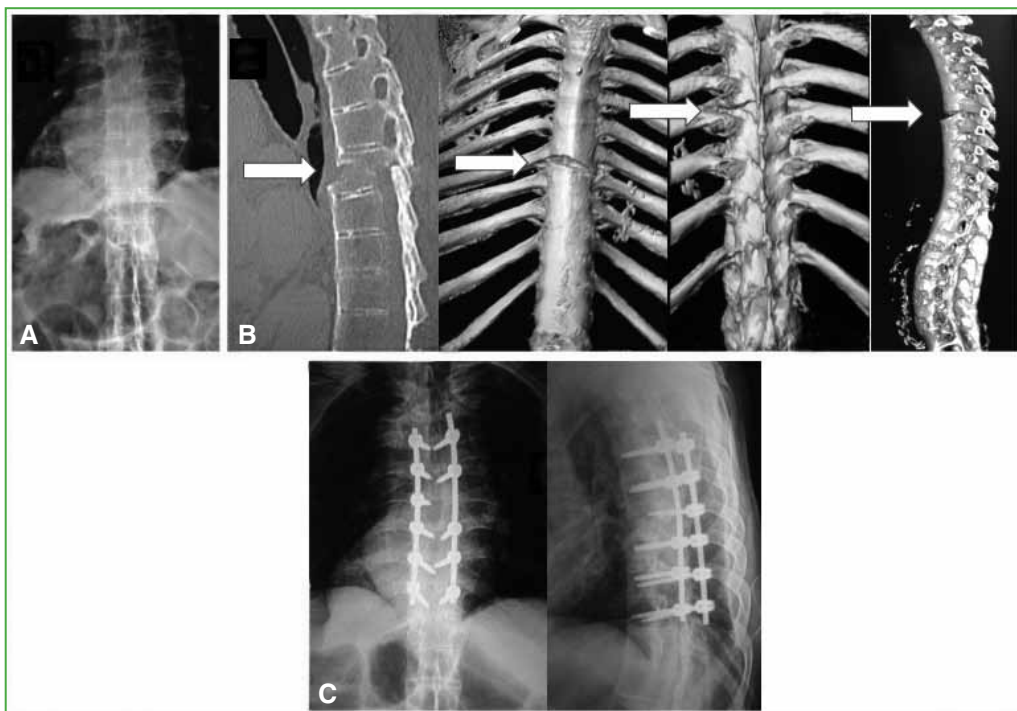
Patient 2. A 77-year-old man who suffered a fall from standing height. A. Frontal radiographs, 48 hours after the fall. B. Three-dimensional tomographic sagittal reconstruction, 22 days after trauma. C. Postoperative radiographs. The white arrow points to the hyperextension injury.
